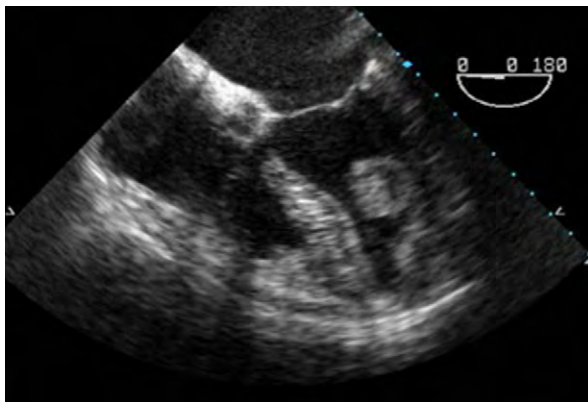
Transesophageal echocardiogram (4-chamber view) shows the intracardiac mass in the left ventricle.
